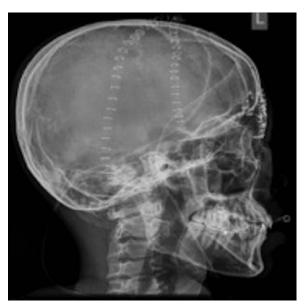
Postoperative x-ray of the repaired fractures.
